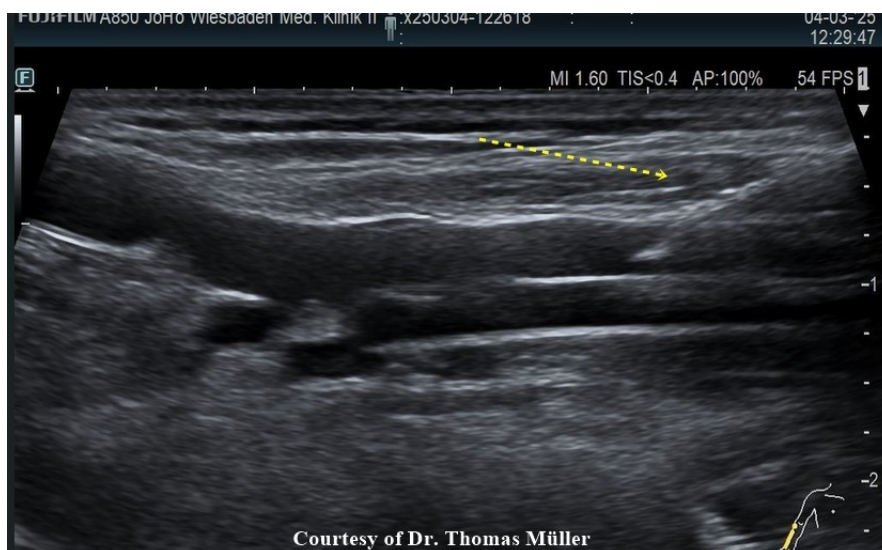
Ultrasound-guided cannulation of the right cubital vein with a high-frequency probe. The needle is visualized in the long axis using the in-plane technique (yellow arrow).
